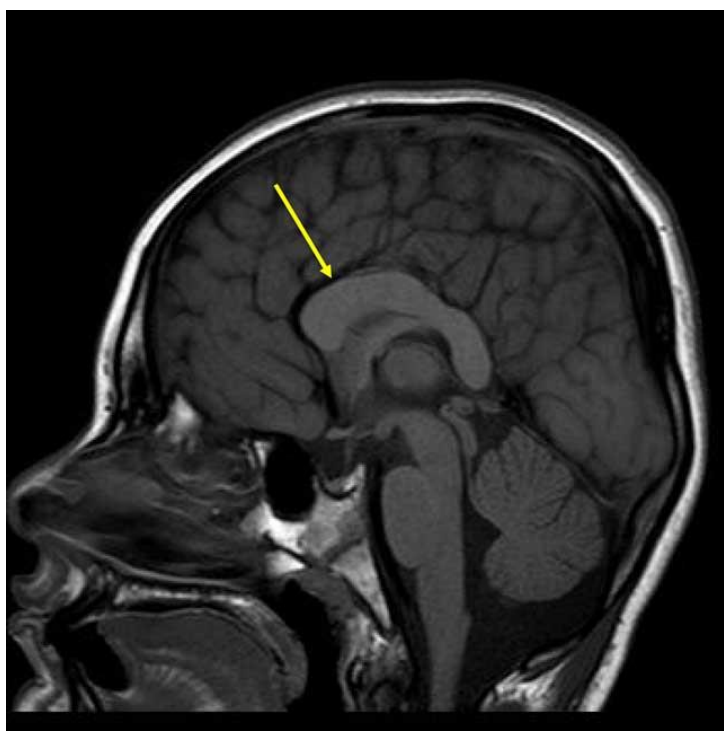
Radiographic image of a brain with Pitt-Hopkins syndrome.¹
